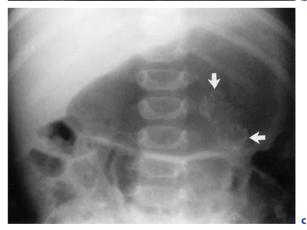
a Ultrasonography demonstrating marked dilatation of the renal pelvis with dilatation of the calyces in a child with pelviureteric junction obstruction. b Ultrasonography 1 month after open pyeloplasty. There was damage to the kidney blood supply at surgery. The kidney is shrunken and is replaced by a rim of increased echogenicity compatible with calcification (*arrow*). c Plain radiography confirming a shrunken left kidney replaced by calcification (*white arrows*)
